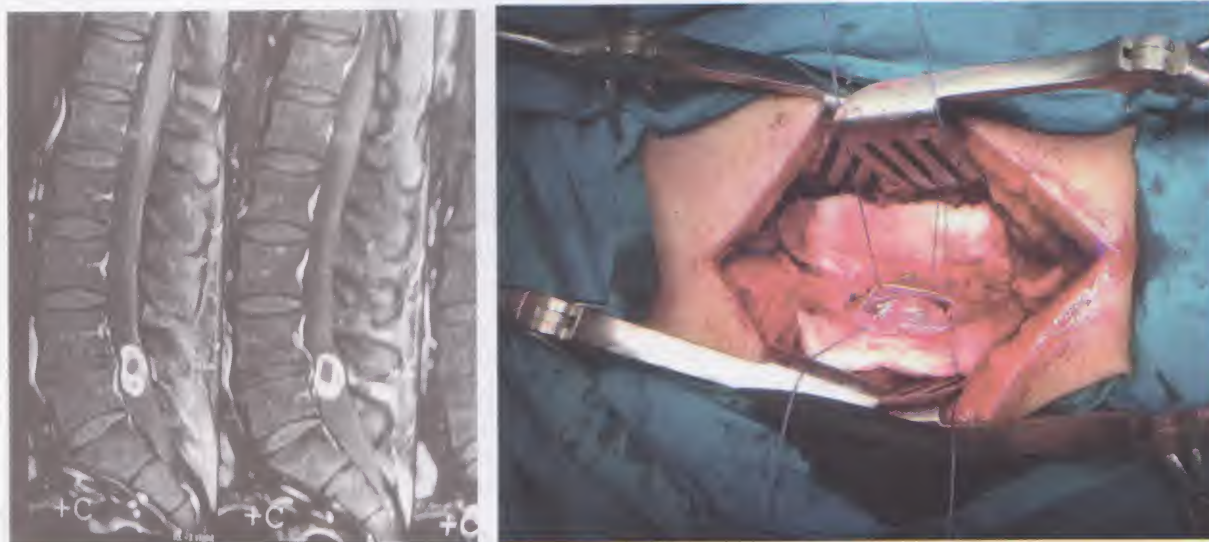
A patient with spinal cord tumor; MRI T1 of lumbo-sacral spine showing an intradural lesion opposite L4-L5 disc with areas of cystic changes.
